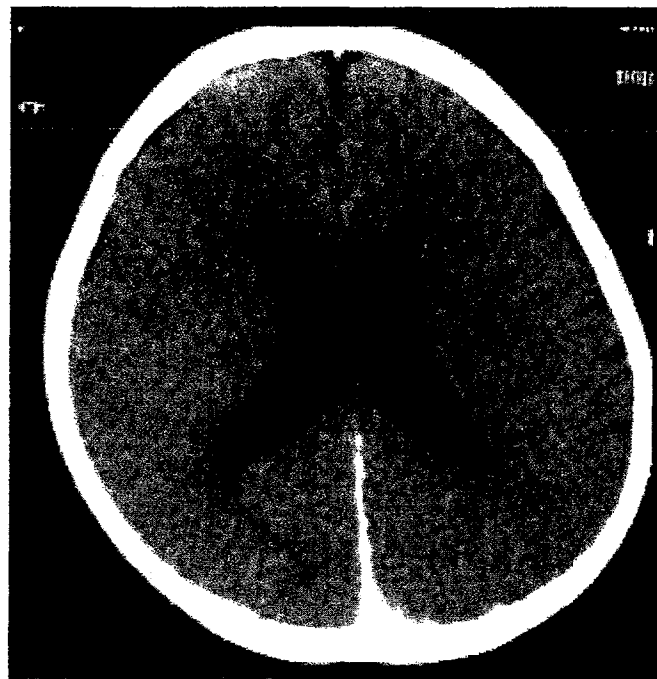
Image obtained from a 23-month-old girl who had recent viral gastrointestinal illness, ALTE, RHs, then brain death. Computed tomographic image shows posterior interhemispheric high densities at the level of portions of the inferior sagittal, straight, and superior sagittal sinuses, plus poor cerebral gray-white matter differentiation and moderate ventriculomegaly. Autopsy showed extensive dural and cerebral venous sinus thrombosis with extensive hypoxic-ischemic diffuse axonal brain injury.
